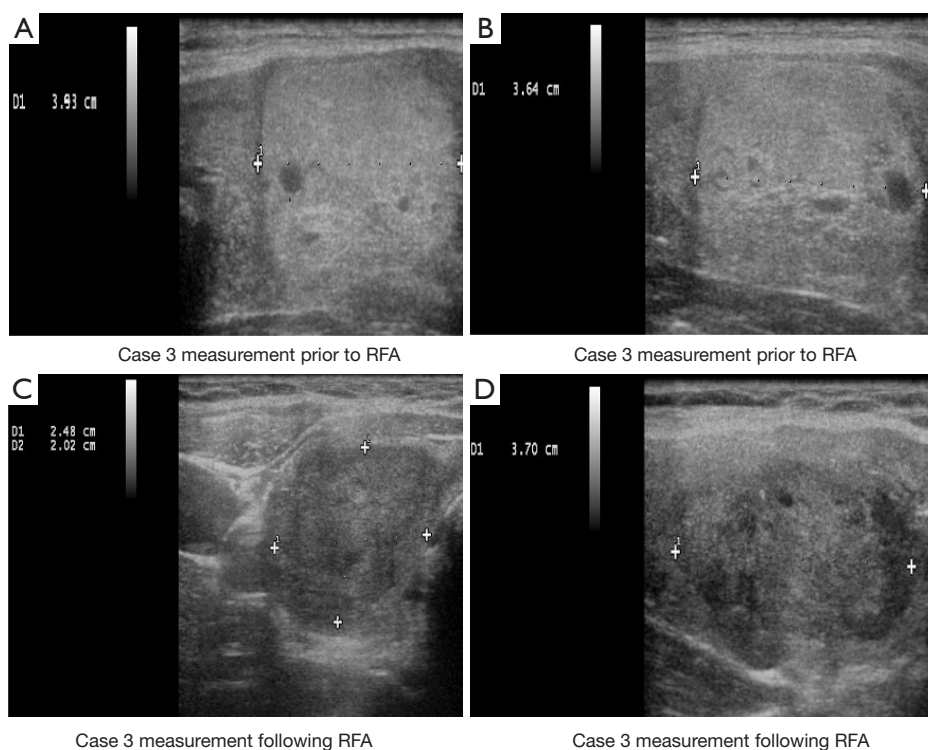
Sonographic images of case 3 prior to and one month following RFA. Volume decreased from 40.57 to 18.54 mL, indicating a 54.32% volume reduction rate. RFA, radiofrequency ablation.
